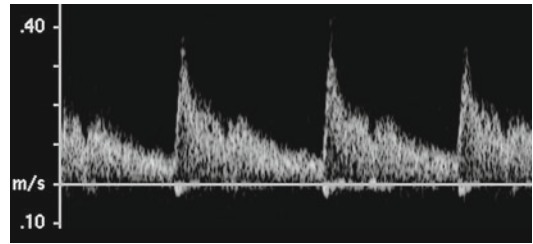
Doppler spectrum (cerebral artery). *Abscissa*: time. *Ordinate*: velocities found along the observing beam; their weight (frequency) is coded as a gray value. Recognizable are the periodic systolic and diastolic distributions of the flow velocities in the vessel being observed. It is easy to see the maxima of the velocities along the upper edges of the shading
